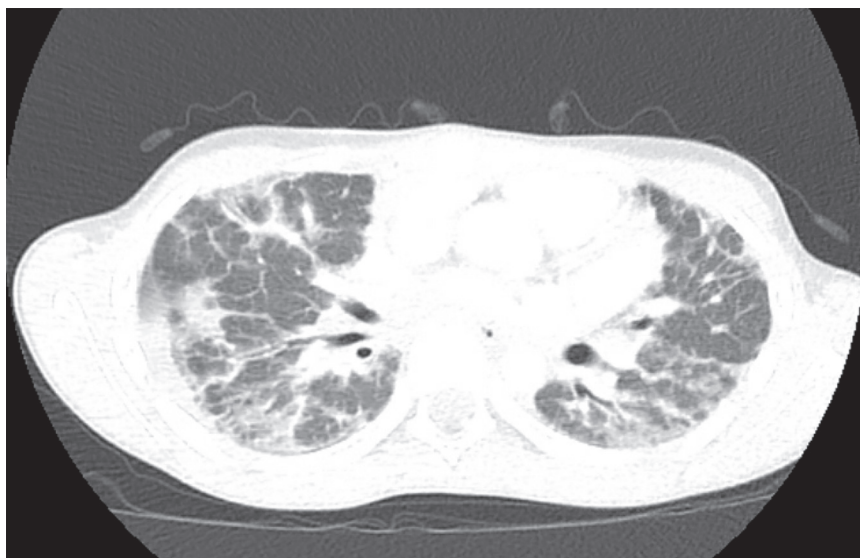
Chest CT with contrast. Multifocal ground-glass opacities with small bilateral pleural effusions and prominent bilateral hilar lymph nodes.
